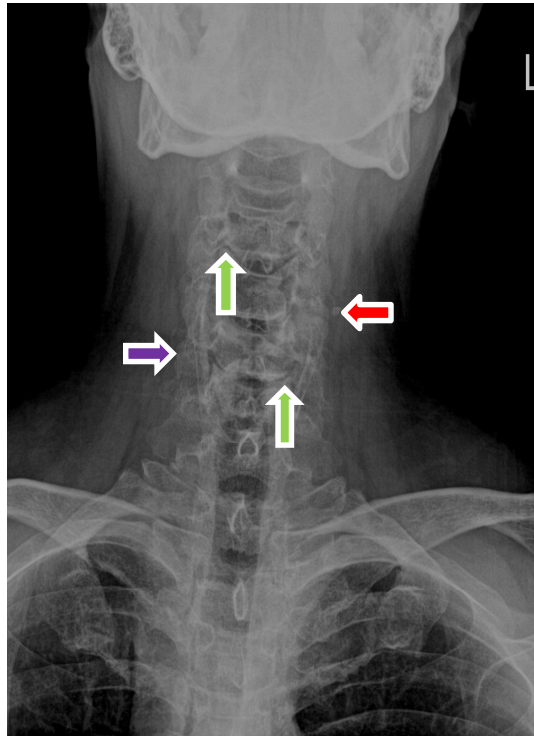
Anteroposterior cervical radiograph demonstrating disc space narrowing, uncinete hypertrophy (green arrows), zygapophyseal (facet) arthrosis (purple arrow), and calcification within the left carotid artery (red arrow).
